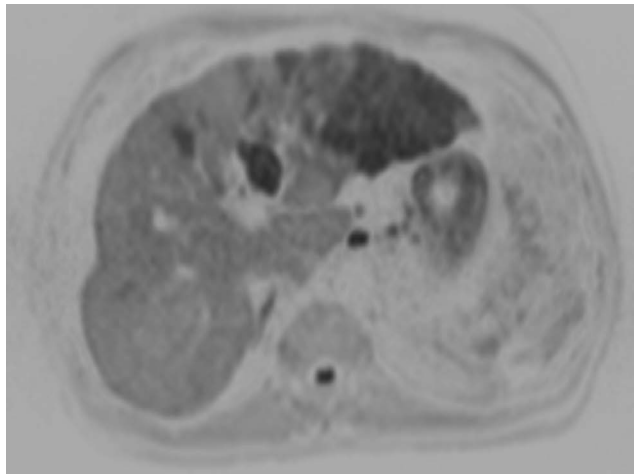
Liver. MRI. DWI (inverted grayscale).
